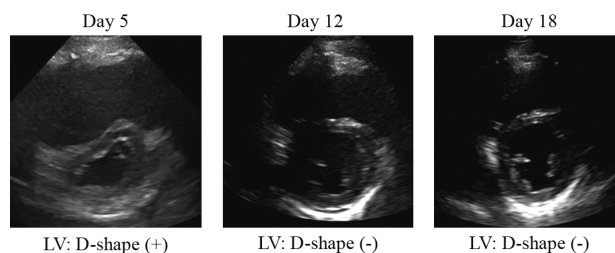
Serial echocardiographic changes in right ventricular pressure overload
